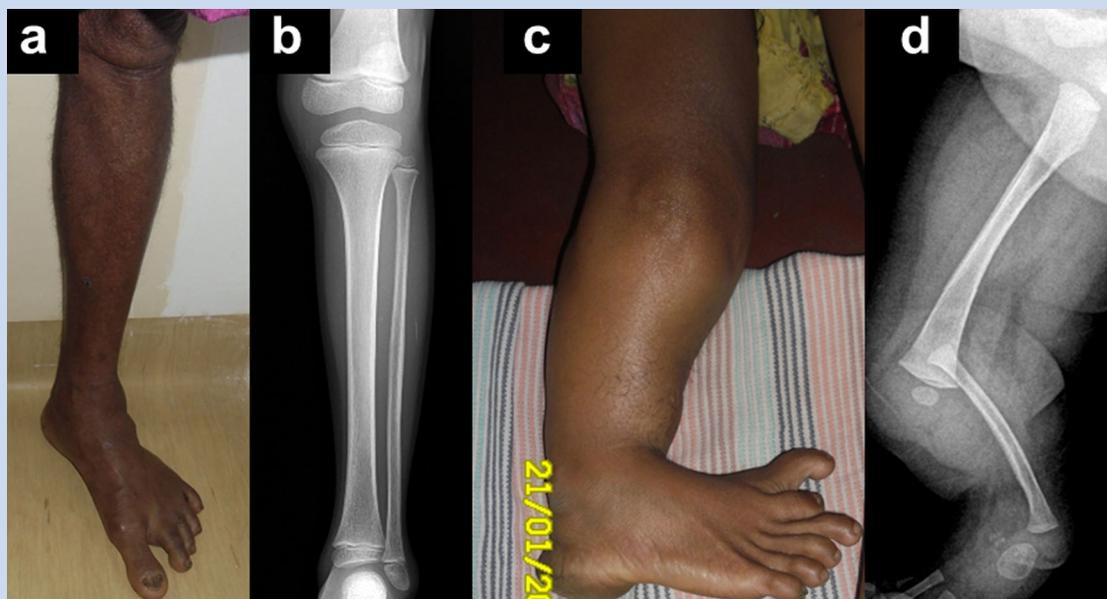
Clinical photograph (a) and radiograph (b) of normal leg (Individual II:5), clinical photograph (Individual II:8) shows mesomelia and clubfoot (c) and radiograph (Individual IV:4) (d) demonstrating complete absence of tibia.
